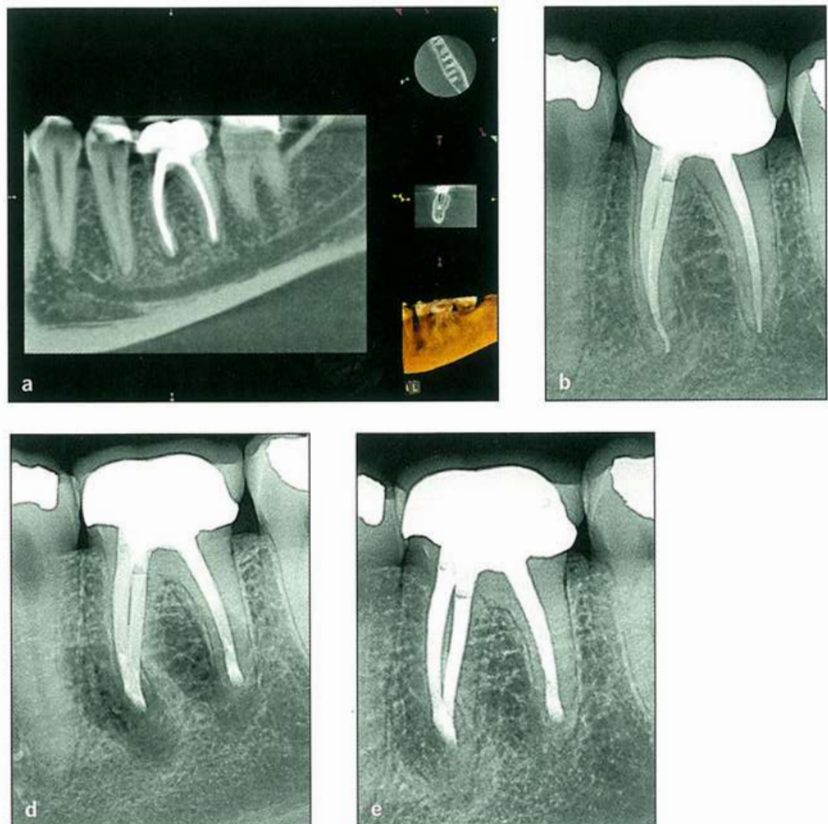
(a) CBCT scan. (b) Preoperative radiograph (note that apical periodontitis is not apparent). (c) Apical retrofillings. (d) Postoperative radiograph. (e) Healing at 6 months.
